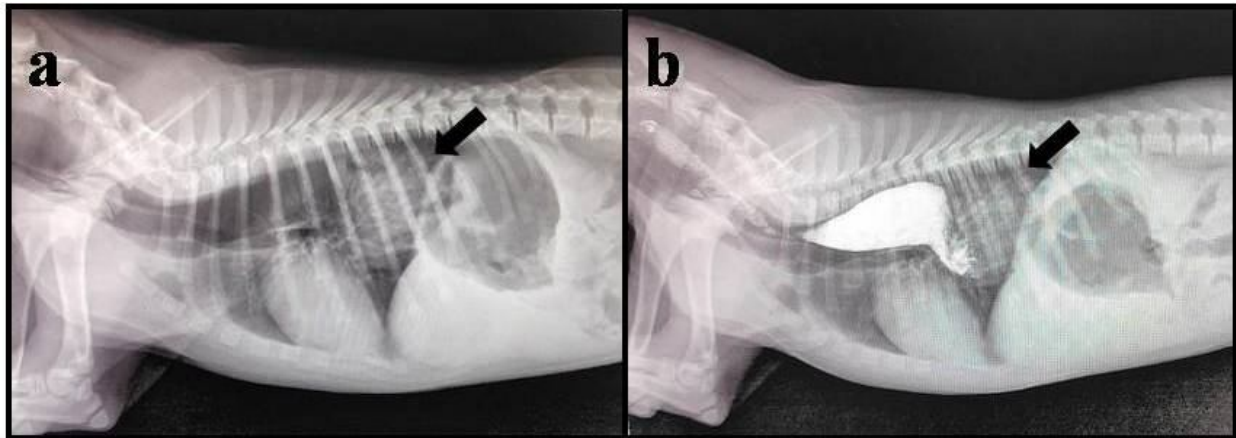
Radiographs (a. plain and b. positive contrast) representing presence of foreign body in caudal thoracic region (black arrow)
